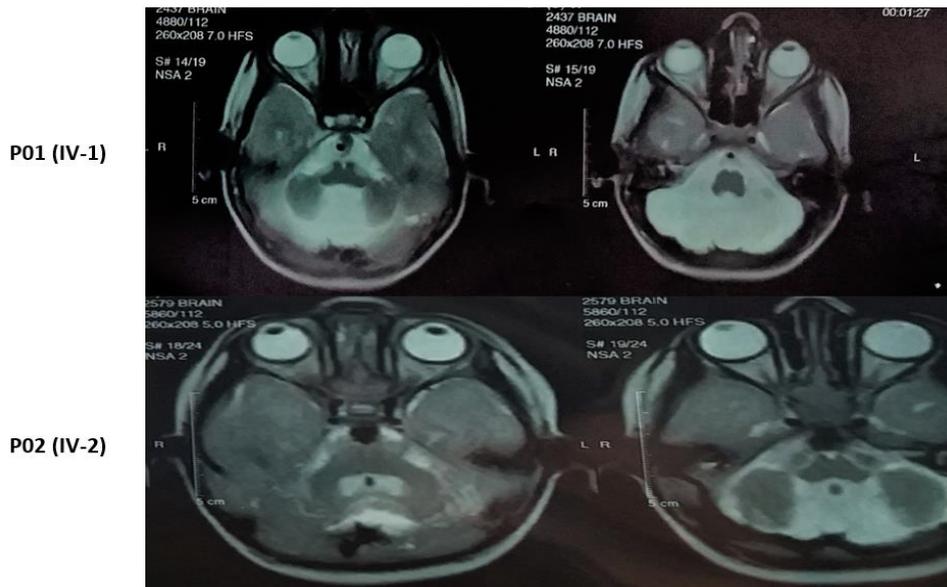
P01 (IV-1) MRI of the brain shows accumulation of CSF in the posterior fossa, also atrophy and hypoplasia of both cerebellar hemispheres and cerebellar vermis noted. P02 (IV-2) Finding of Brain MRI was there is evidence of increase extra axial CSF space is seen along bilateral cerebellar convexity as well as hypoplastic both cerebellar hemispheres and vermis. Findings were suggestive of cerebellar atrophy.
